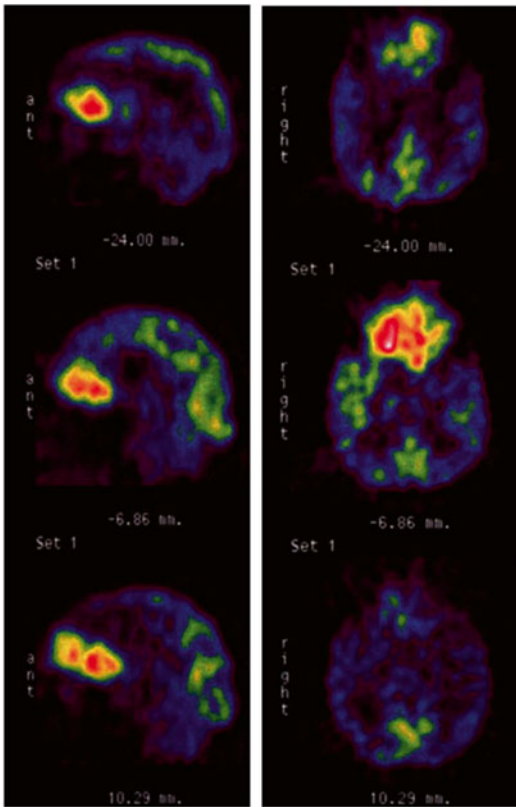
Pre-operative PET images of a frontal lobe glioblastoma in a 54-year-old with headaches and forgetfulness. 18F-FDG PET (sagittal at *left*, axial at *right*) SUV max = 12, mean SUV = 9.25
